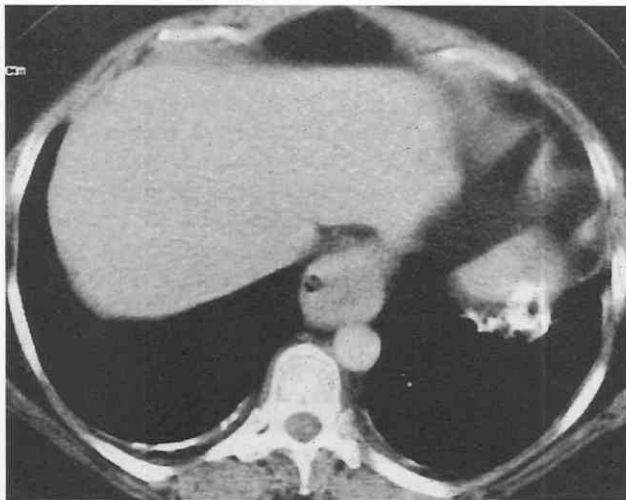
Asbestos exposure. Contrast-enhanced CT scan shows bilateral calcified pleural plaques posteriorly with involvement of the left diaphragm.
